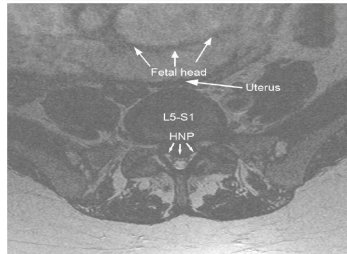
Axial T2 weighted MRI image demonstrating a HNP at L5-S1 level with a marked compression of the proximal S1 nerve roots bilaterally (small arrows), and gravid uterus (big arrows) in close proximity to the L5-S1 disc.
